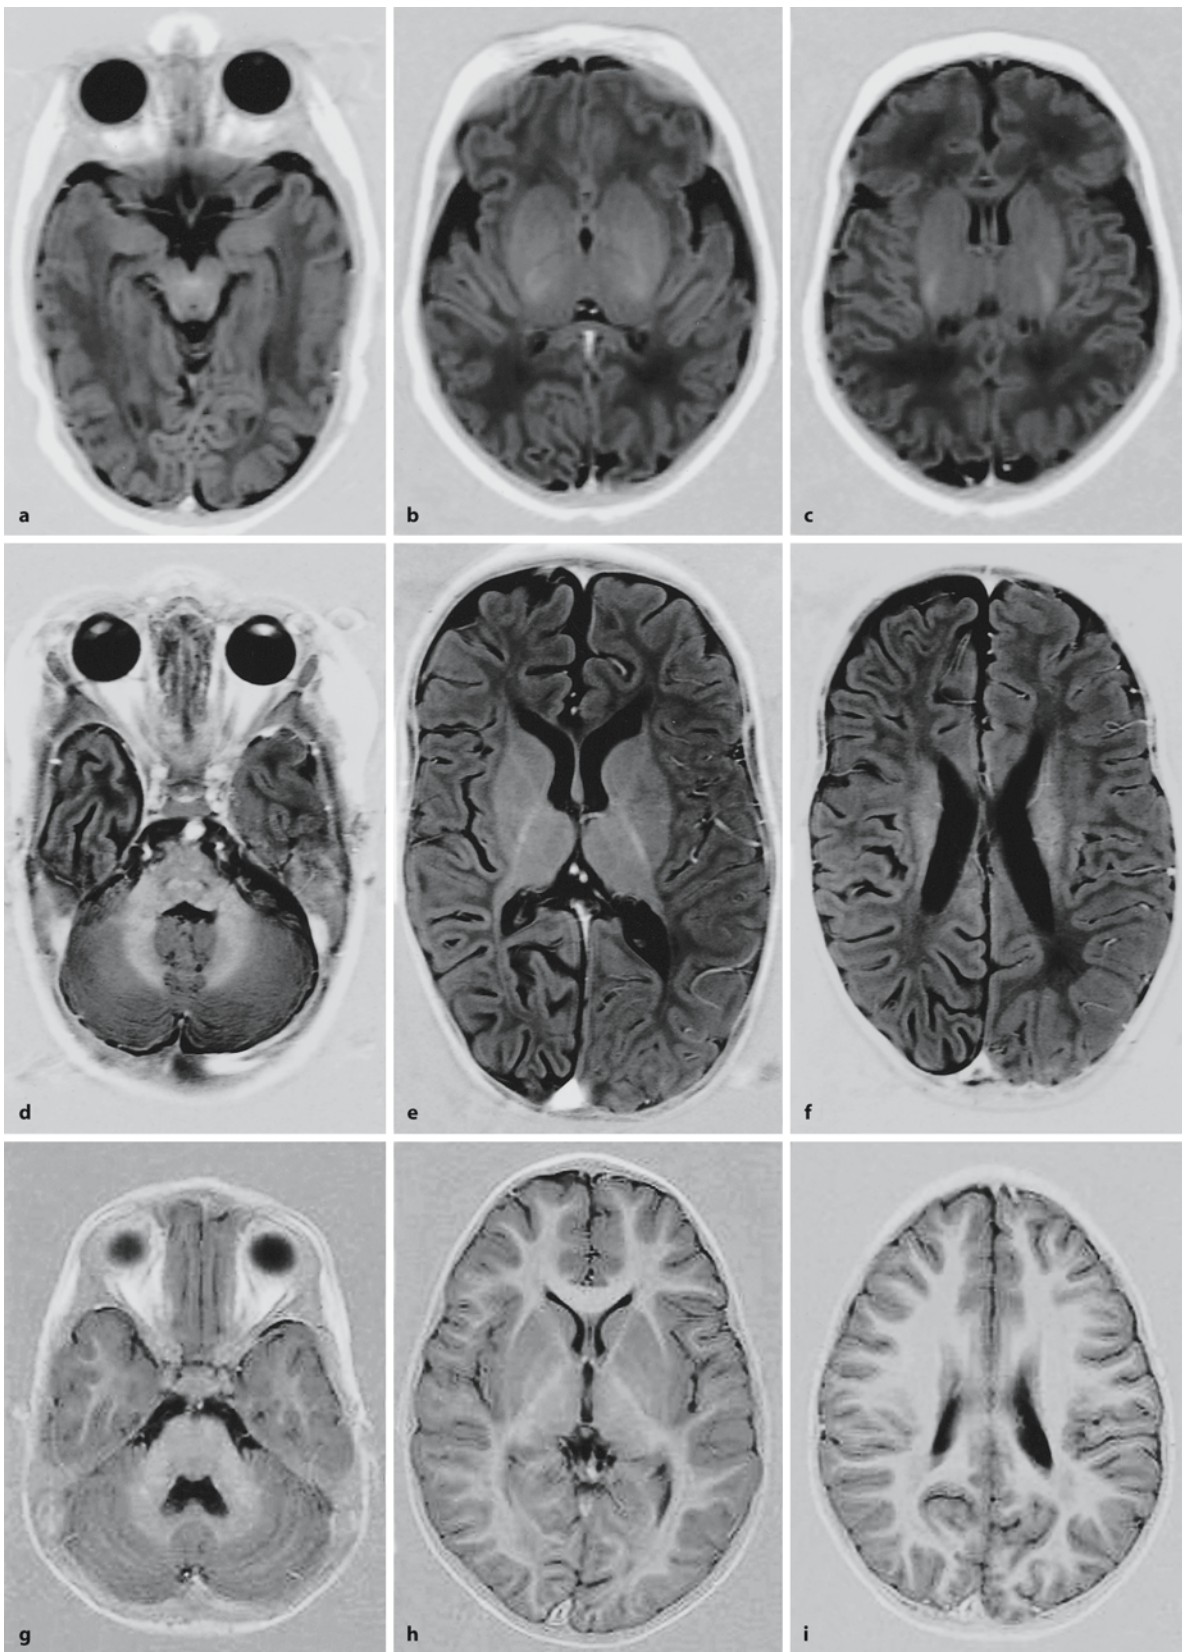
Myelination in T1-weighted horizontal (or axial) images of a newborn (a–c), a child of 1.5 years of age (d–f) and a young adult (g–i). In a myelination is visible in the decussation
